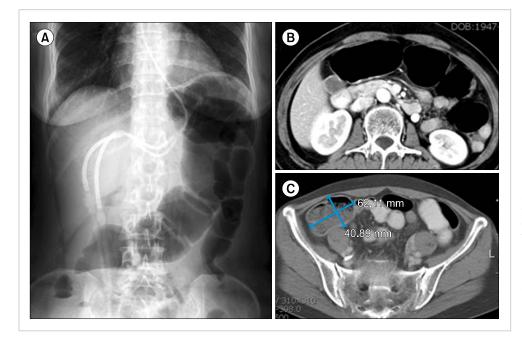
Plain abdominal radiograph on day +20 post-transplant reveals the presence of a dilated colon (A). A gaseous dilated transverse and ascending colon is shown on a computed tomography scan (B) obtained on the same day (day +20). There was no evidence of mechanical obstruction, bowel wall thickening, or abnormal enhancement. The blue lines indicate cecal diameter (C).
